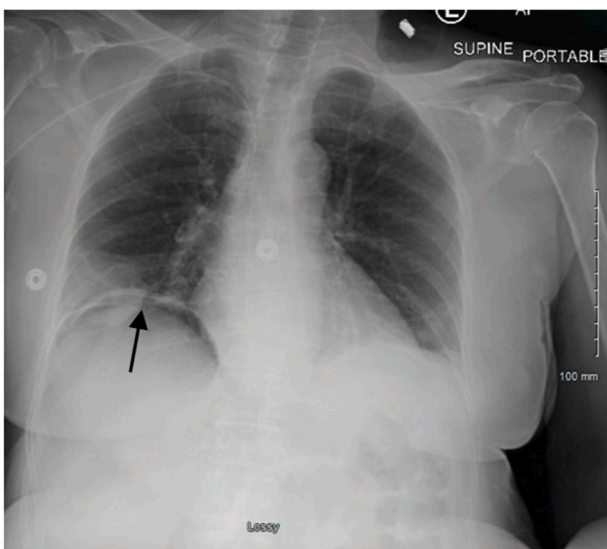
Chest x-ray showing pneumoperitoneum (black arrow).
